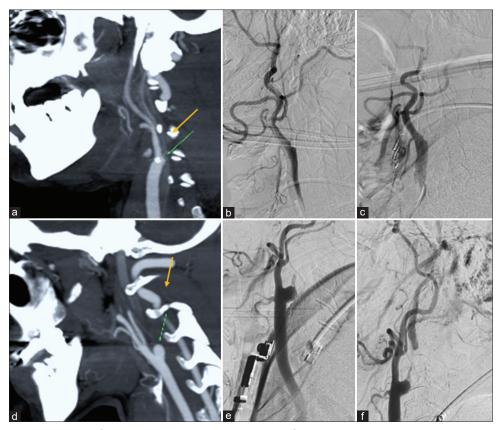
Imaging patterns of proximal ICA occlusion (a) flat shaped occlusion in CT angiography, (b) flat shaped occlusion in corresponding DSA (c) true occlusion demonstrated after microcatheter injection (d) dome shaped occlusion in CT angiography, (e) dome shaped occlusion in corresponding DSA (f) true occlusion demonstrated after microcatheter injection. ICA = internal carotid artery, CT = computed tomography, DSA = digital subtraction angiography
